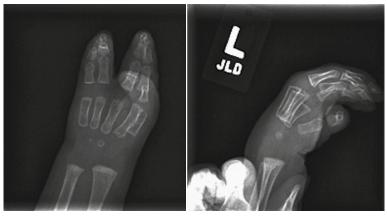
Hand radiograph of an infant demonstrating acrosyndactyly. (From The Ohio State University Wexner Medical Center, Columbus, Ohio.)
